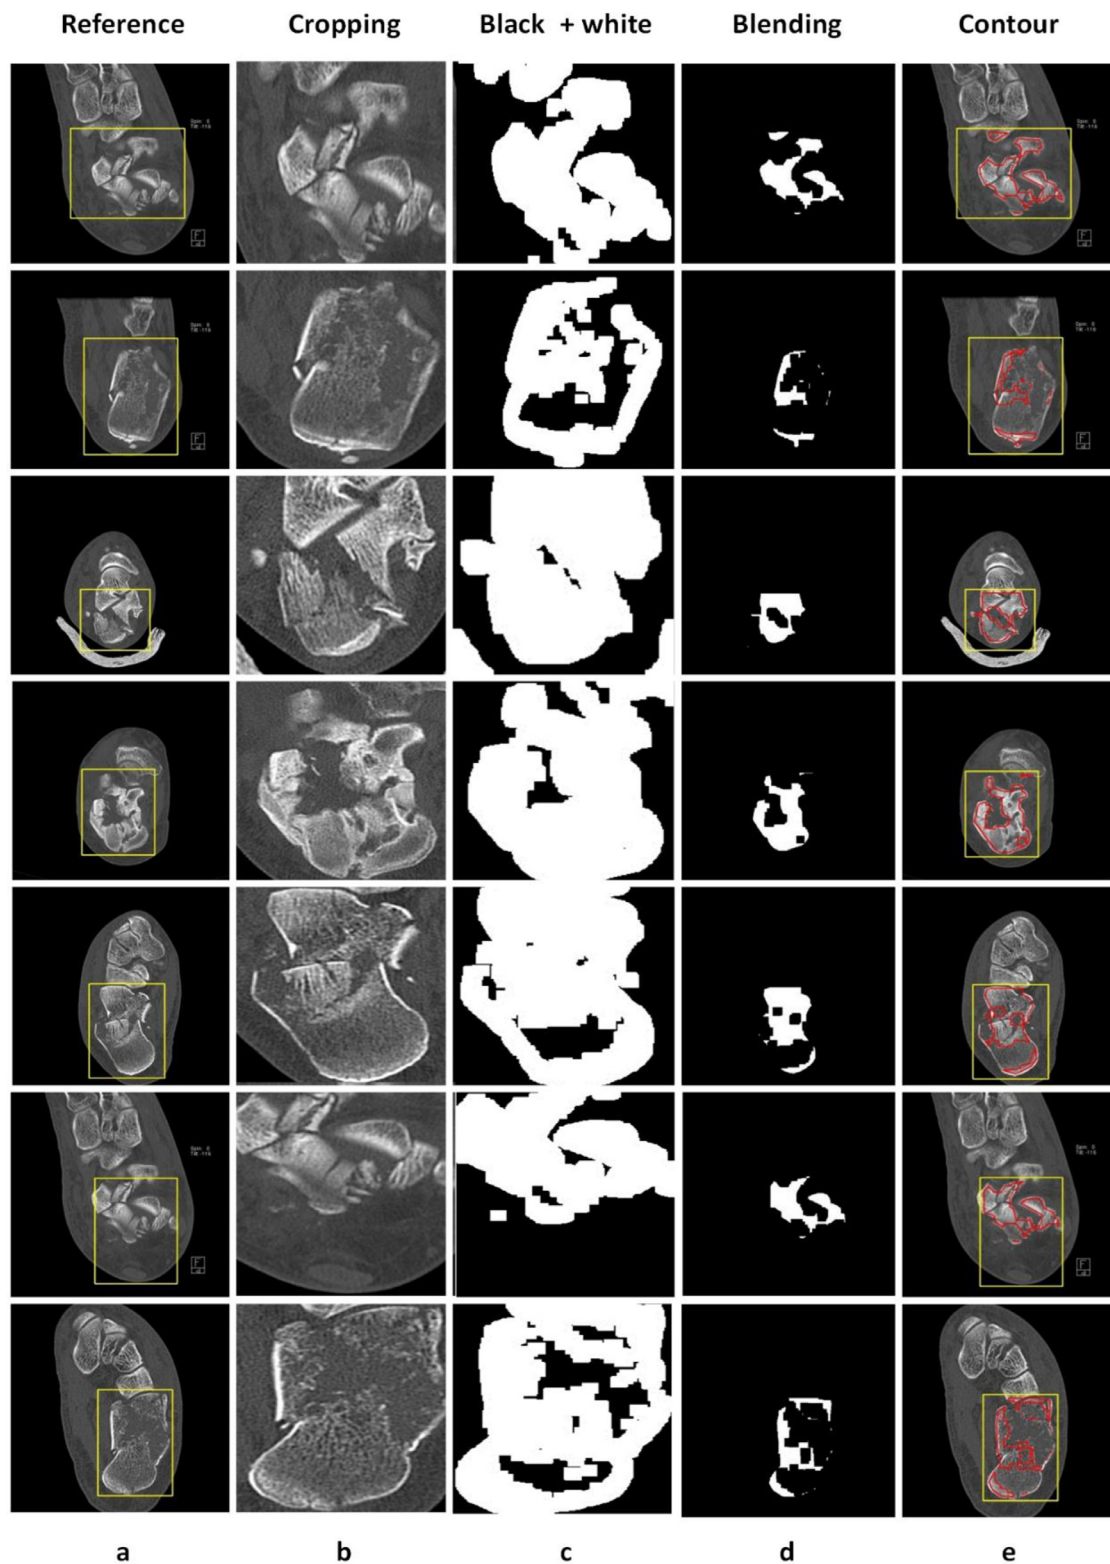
Detection results for fractured calcaneus CT images at various processing steps. (a) the original image, (b) the cropped image using SURF matching to a reference image, (c) the image after grey scaling, (d) the image after Canny edge detection, and (e) the image after contour detection.
